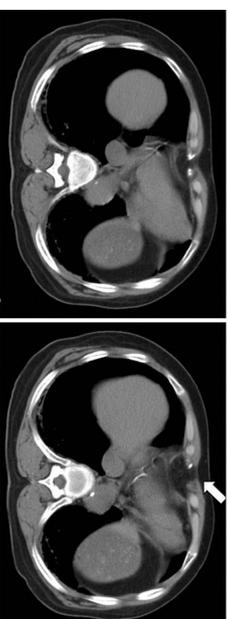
Computed tomography imaging of SIH and a fascial defect (arrow)
